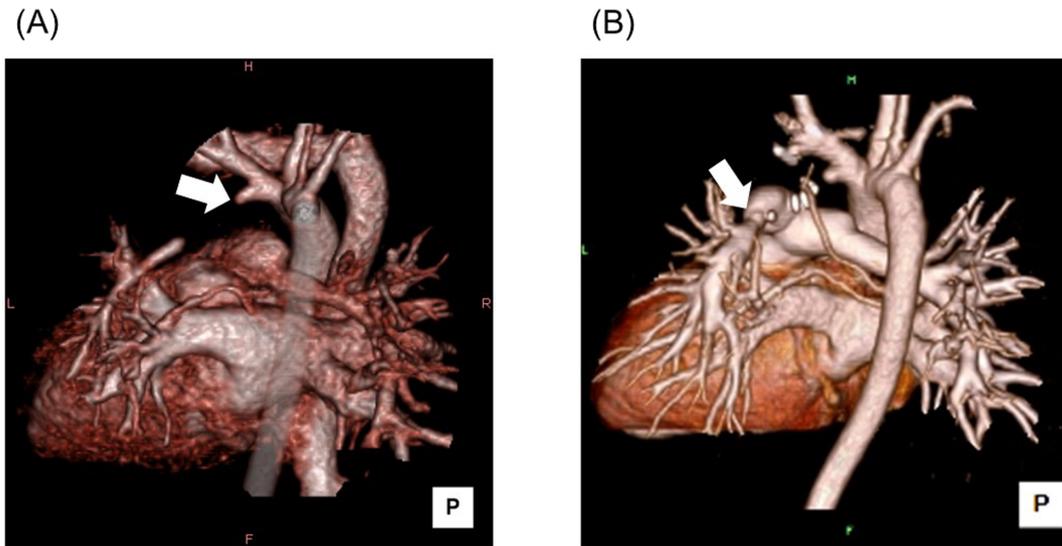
Posterior views of 3D computed tomography of Patient 1
